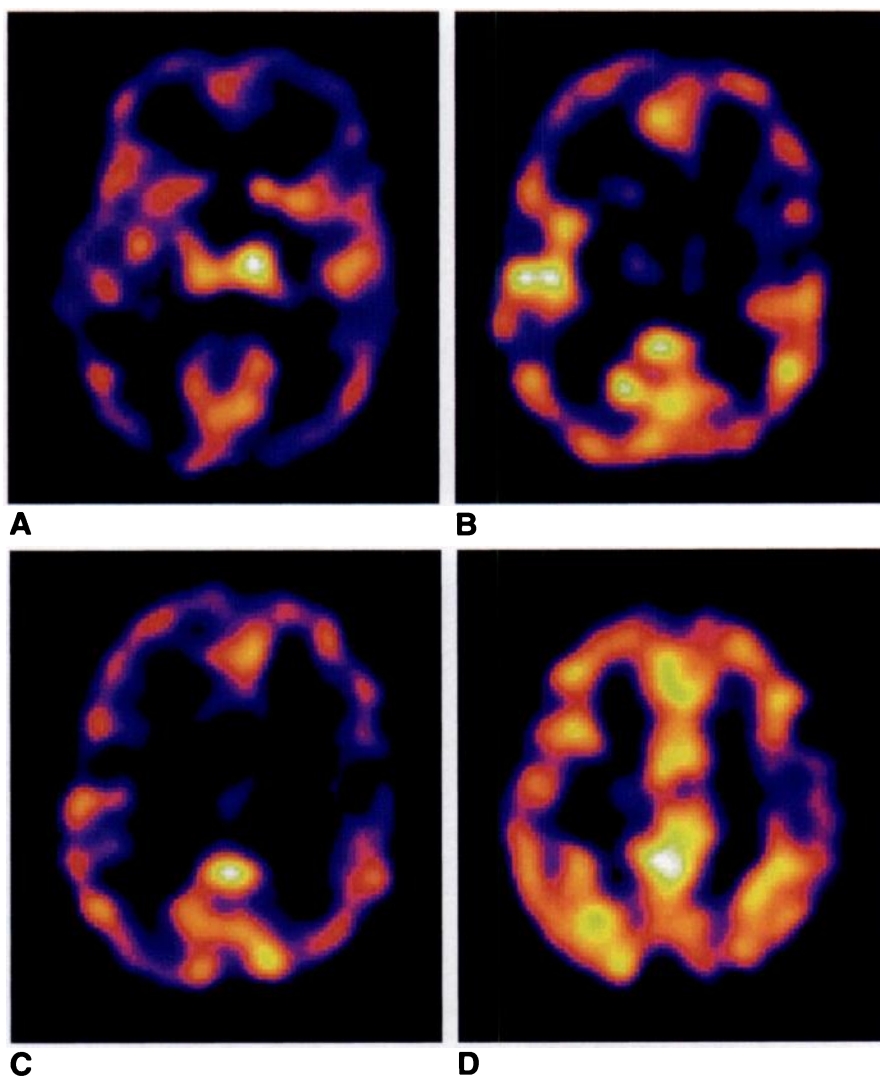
A–D, Axial SPECT images (5-mm-thick sections) of a 42-year-old woman with chronic fatigue syndrome. Color scale ranges from black (low activity) to white (high activity). Multiple perfusion defects are present throughout the brain.
